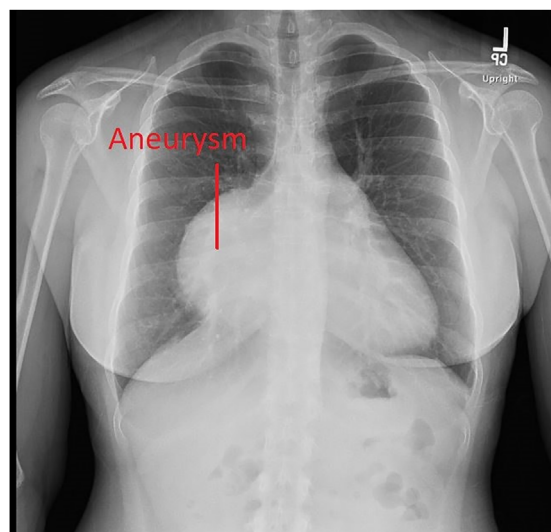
Preoperative chest radiograph demonstrating a large mass silhouetting the right border of the heart
